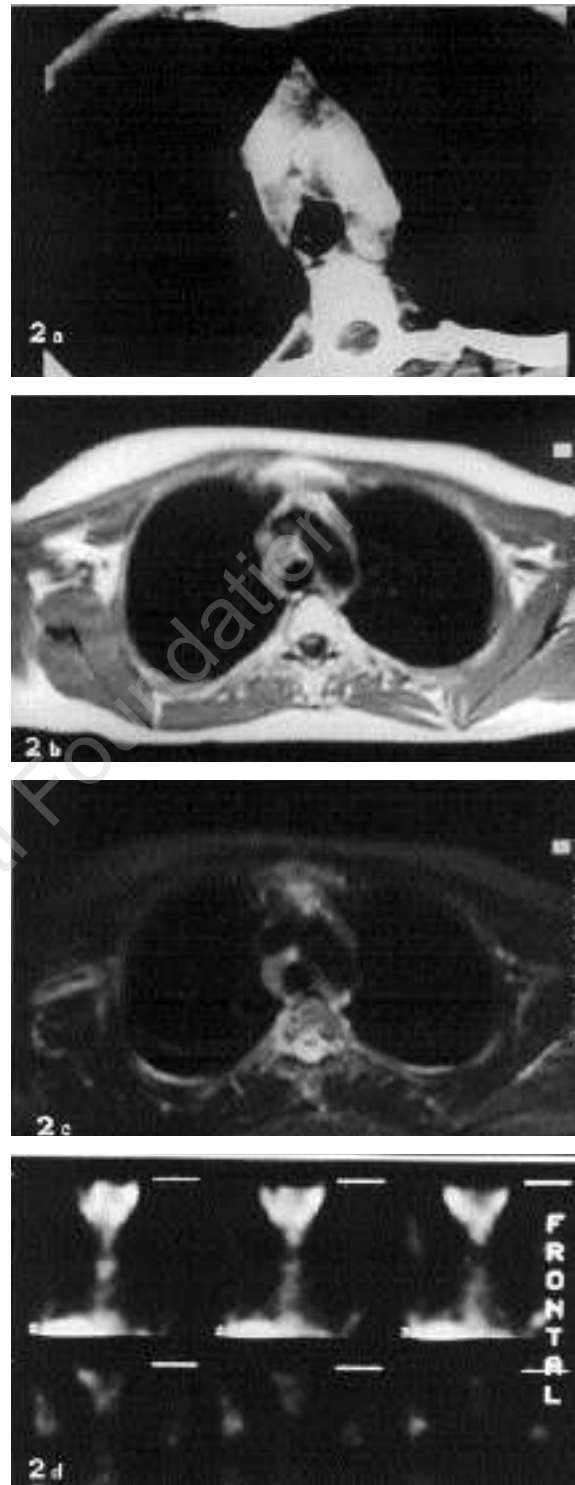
Case 1. Mediastinal images after radiotherapy, with computed tomography (2a), magnetic resonance T1 (2b)-T2 (2c) and gallium 67 scintigraphy (2d). The hypointensity in T2 sequence and the absence of gallium 67 uptake led to the conclusion that the radiologic image was not consistent with residual Hodgkin's disease.
